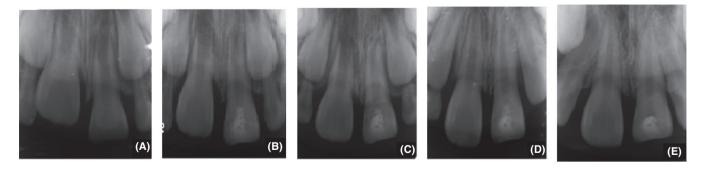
An example of a successful case involving a 9-year-old boy with a complicated crown fracture in the left incisor. A, The preoperative radiograph before partial pulpotomy. B, Follow-up radiograph 3 mo after CH partial pulpotomy. A calcific bridge can be seen. C, Follow-up radiograph at 6 mo. D, Follow-up radiograph at 12 mo. The roots are longer, and the dentin is thicker. E, Follow-up radiograph at 24 mo. The apical foreman is smaller, and the root canal space is narrower. The capping agent has partially disappeared by this stage, so it appears unclear on the radiograph
